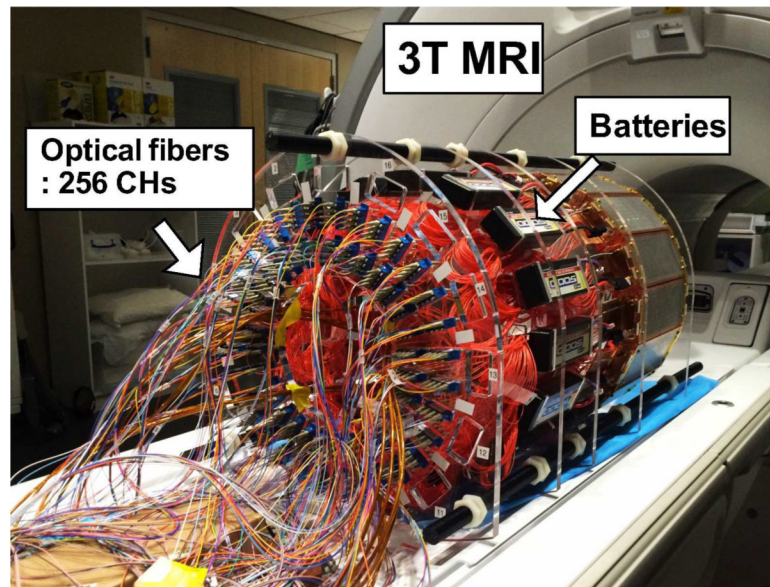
PET insert on the patient bed of a 3T MRI system. The insert is powered with batteries and connected to the data acquisition system with 20 m length optical fibers. The data acquisition system resided in the adjacent control room.
